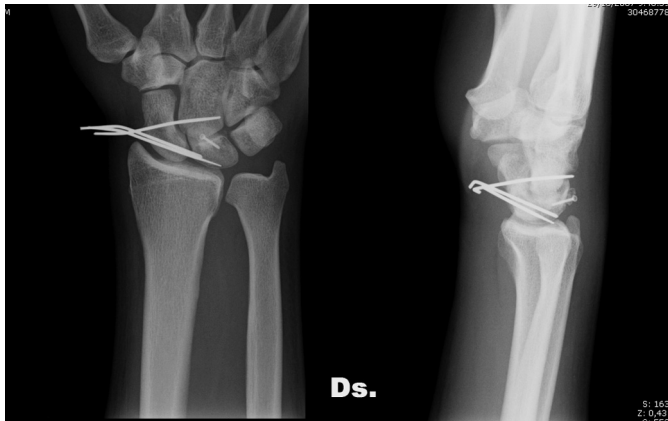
Post-operative X-rays showing reduction and pinning of the scapholunate interval (two scapholunate K-wires and one scaphocapitate K-wire) and screw fixation of the avulsed lunate fragment.
